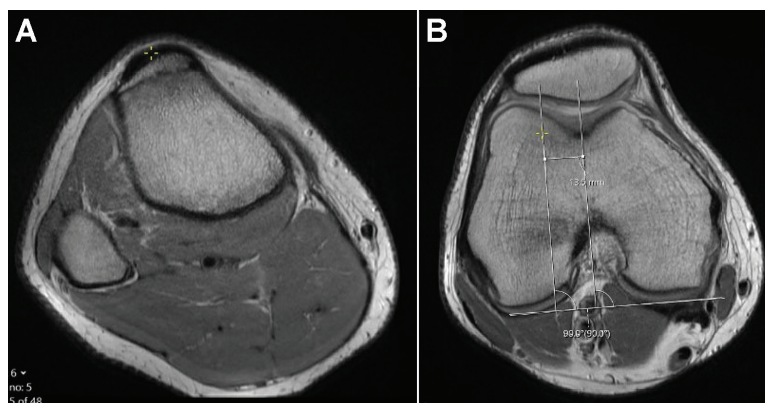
Tibial tuberosity-trochlear groove distance. (A) On axial view MRI, locate the most proximal slice with complete articular cartilage covering the trochlea. Draw a line parallel to the posterior femoral condyles. Draw a line perpendicular to this line. Move the perpendicular line so that it sits at the deepest part of the trochlear groove. Locate the tibial apophysis. Select the most distal axial slice at which the patellar tendon inserts on the tibial tubercle—usually the slice where the tibial apophysis looks the largest. Place the crosshair in the center of the patellar tendon from medial to lateral. (B) On the trochlear view, draw a line through the crosshair that is parallel to the line through the trochlear groove and perpendicular to the line through the posterior condyles. Measure the distance between the 2 parallel lines. MRI, magnetic resonance imaging.
